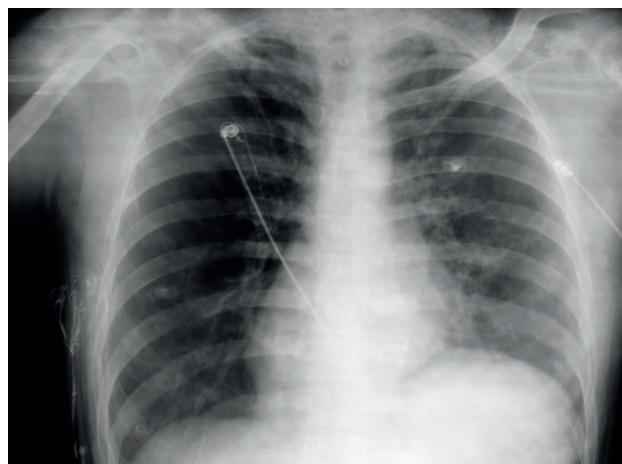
Postoperative chest radiograph on the first day
